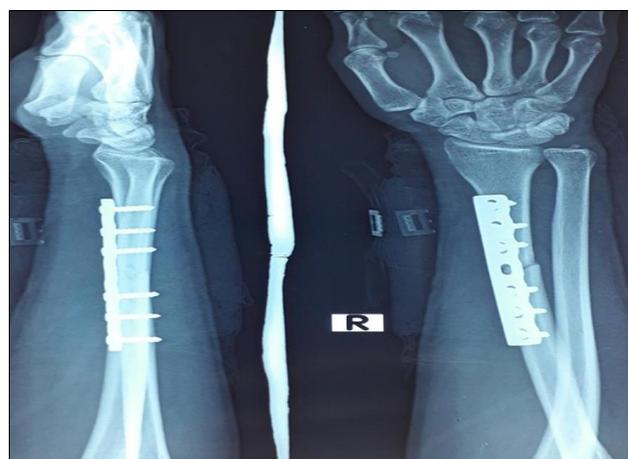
3 Months post op x-ray
